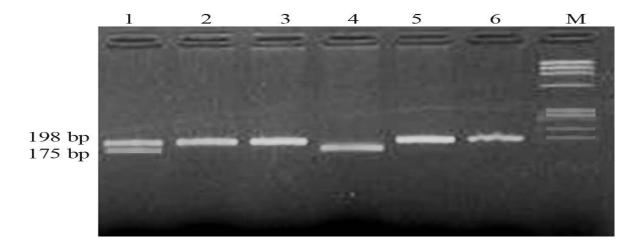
Detection of MTHFR polymorphism. Lanes 2, 3, 5 and 6 showing wild type (CC) genotype, lane 1 showing mutant heterozygous (CT) genotype and lane 4 showing mutant homozygous (TT) genotype, M showing molecular weight Marker.
